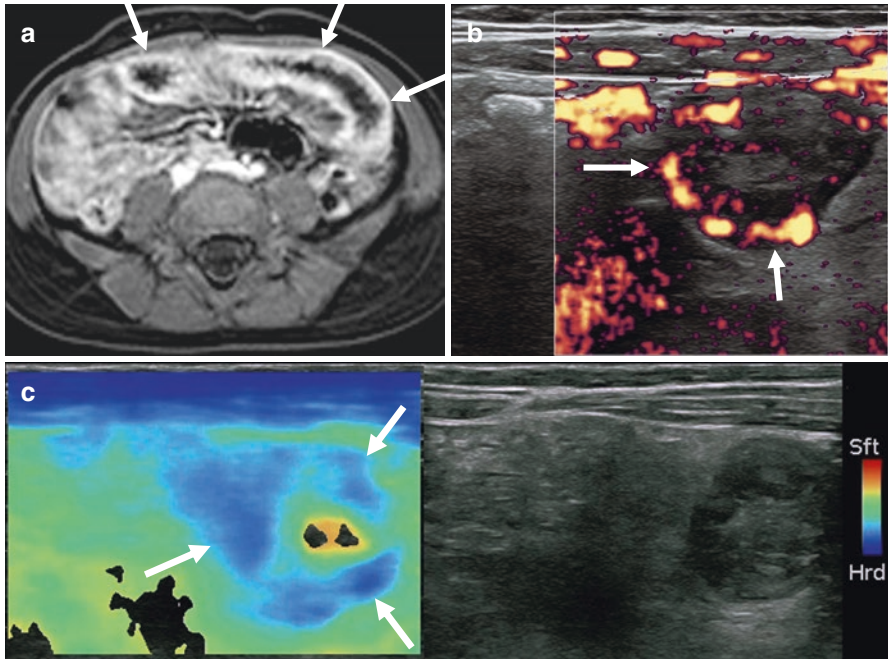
A 6-year-old girl with newly diagnosed Crohn's disease. (a) Axial postcontrast T1-weighted fat-suppressed MR image shows extensive jejunal wall thickening and mural hyperenhancement (*arrows*), consistent with active inflammation. Mesenteric vascular structures are engorged. (b) Power Doppler image of the left anterior abdomen shows a thick-walled small bowel loop (*arrows*) with associated mural and mesenteric hyperemia. Adjacent mesenteric fat appears thickened. (c) Strain elastography stiffness map (elastogram) with side-by-side gray-scale image shows that the bowel wall (*arrows*) is substantially harder than adjacent mesentery (blue is hard and red is soft)
